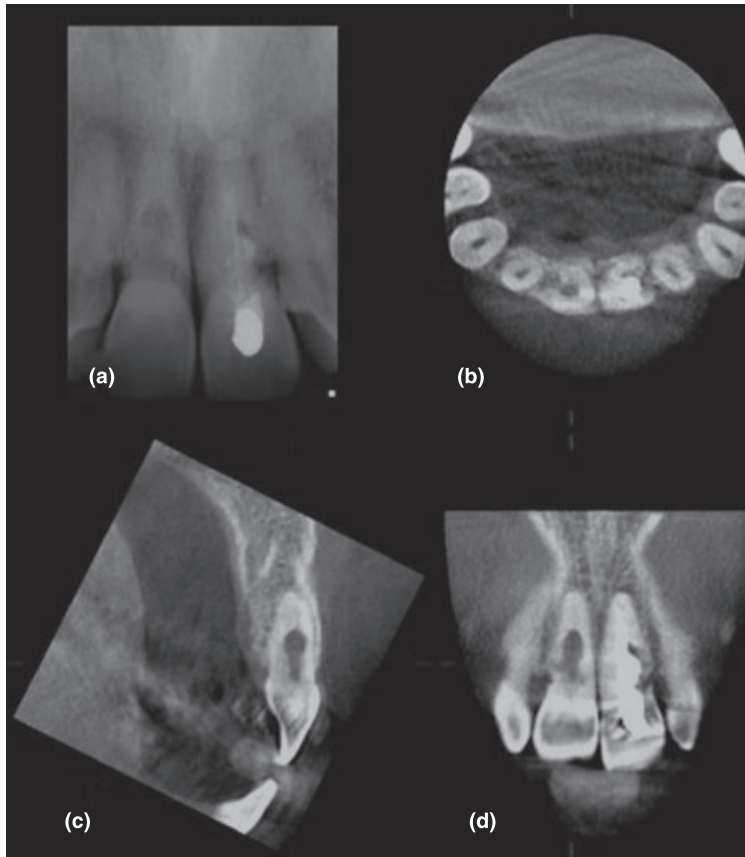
(a) A radiograph and (b–d) typical images produced by a limited cone beam computed tomography scanner (3D Accuitomo 80; J Morita, Kyoto, Japan), (b) axial, (c) sagittal and (d) coronal views of a patient with internal resorption of the maxillary right incisor and external cervical resorption of the maxillary left incisor teeth. The software reconstructs three-dimensional images with minutes of the scan being taken. The images can be re-sliced at any angle, producing a new set of reconstructed orthogonal images.
